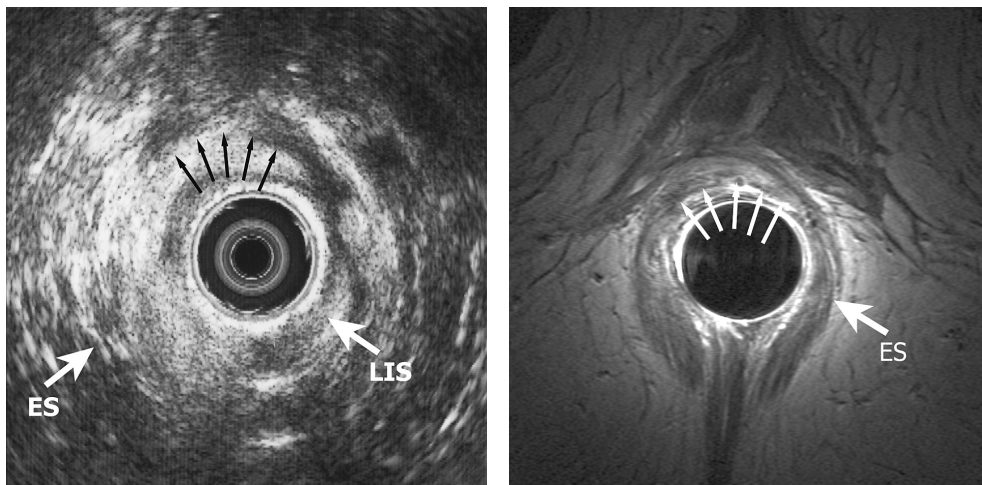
(4a) Transverse endoanal ultrasonography and (4b) transverse endoanal T2-weighted fast spin-echo (2500/70) MR image at the mid - distal anal canal obtained from a 53-years-old woman after a complicated vaginal delivery (rupture) demonstrating sphincter overlap (thin arrows) of both external anal sphincter ends, left over right, after anterior anal sphincter repair and continuity of the sphincter ring has been restored. Although appearances at endoluminal imaging show overlap, surgery failed for this patient as the patient was still fecal incontinent.
